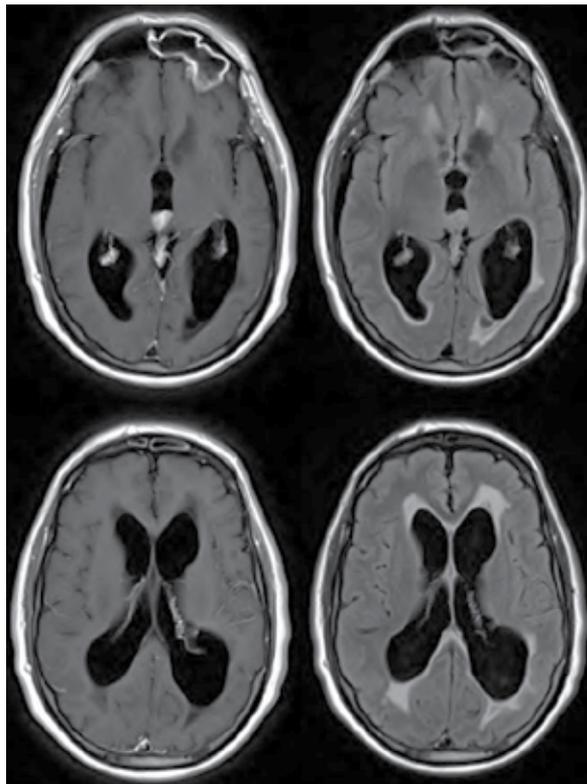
MRI scan from an elderly patient with a pineal mass and associated hydrocephalus who presented with acute confusion consisting of difficulty driving and paying bills.
